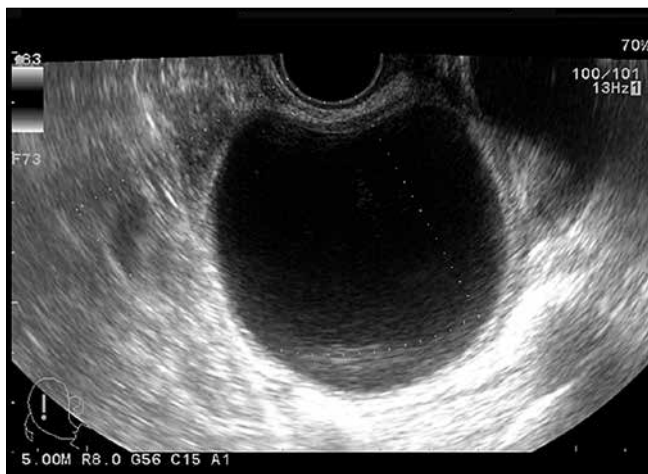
False negative result of ultrasonography in 21-year-old woman with borderline serous tumor.
